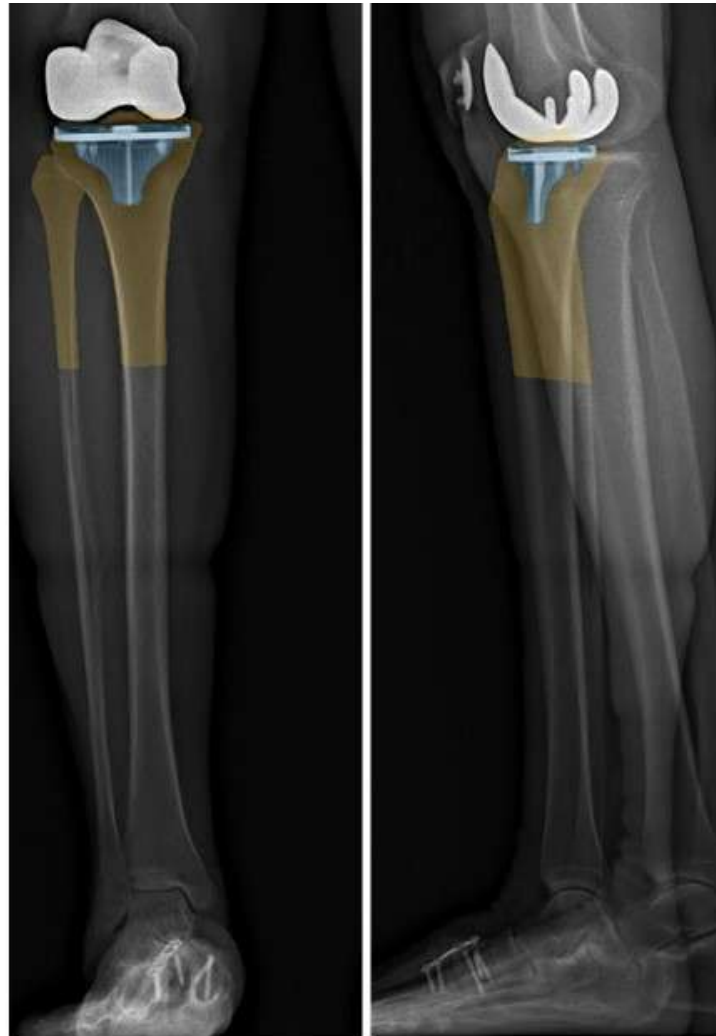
Projection and alignment of bone and implant onto biplane radiographs
